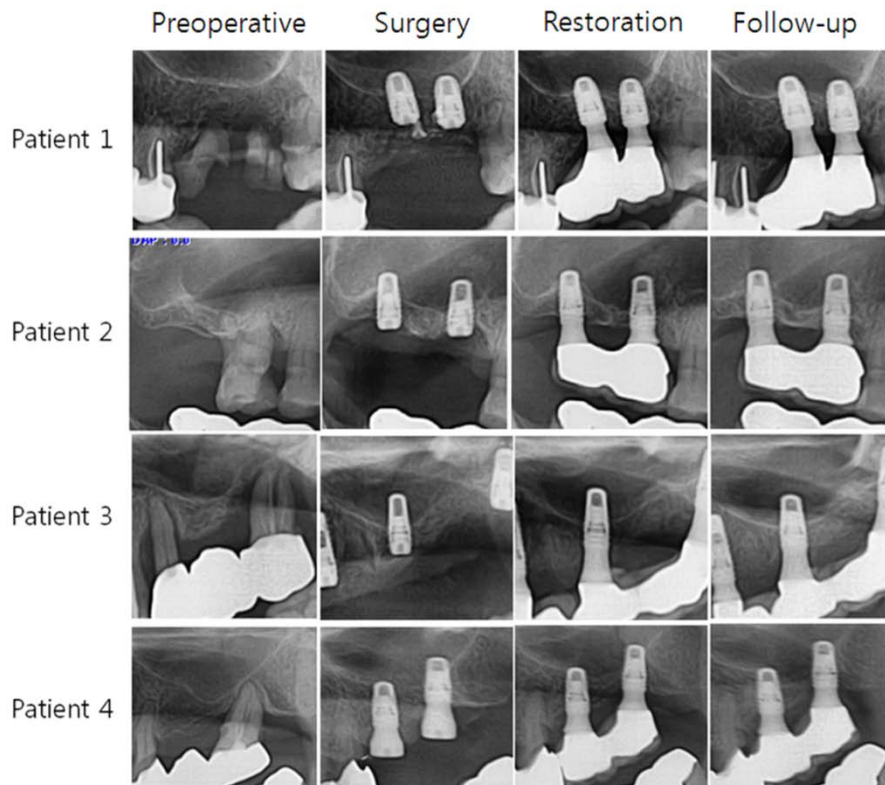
Panoramic X-ray of each patient at every visit during 1 year. At preoperative visit, postsurgery, restoration on 6 months after surgery, and the last follow-up
